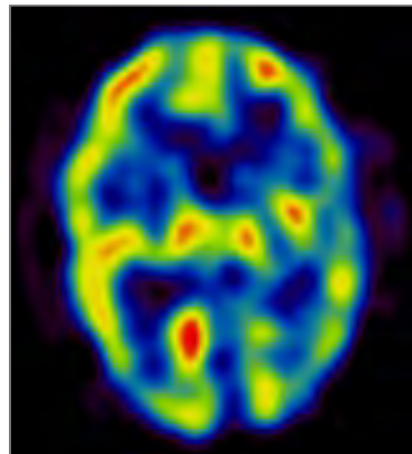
SPECT images of a patient with intractable non-lesional extratemporal seizures. The initial SPECT studies were done with ^{99m}Tc -HMPAO: ((A) postictal image, (B) interictal image, and (C) SISCOM). The injection was postictal, resulting in a non-localising SISCOM image. A repeat ictal study and an interictal study were performed using ^{99m}Tc -ECD ((D) ictal image, (E) interictal image, and (F) SISCOM). The ictal injection of ^{99m}Tc -ECD resulted in a localised SISCOM abnormality in the left mesial frontal lobe, which was concordant with seizure semiology and with ictal EEG localisation.
